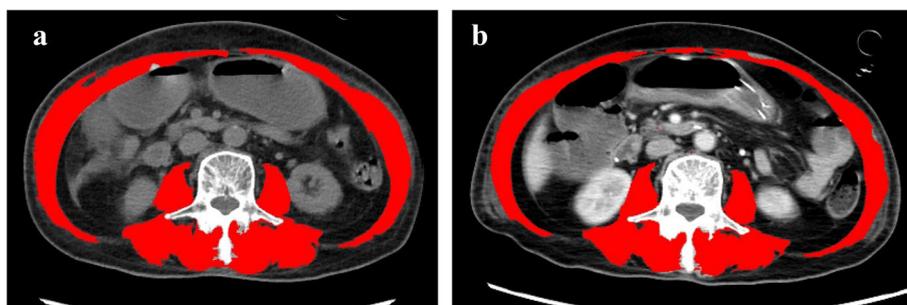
Typical transverse CT images at L3 of the same patient. a ICU admission; b, the tenth day after ICU admission. The total skeletal muscle area (red)
